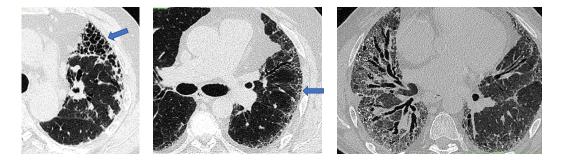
Examples of chest CT scans affected by IPF: LEFT: Example of honeycombing (blue arrow). MIDDLE: Examples of reticular pattern (blue arrow). RIGHT: Example of traction bronchiectasis caused by IPF.
